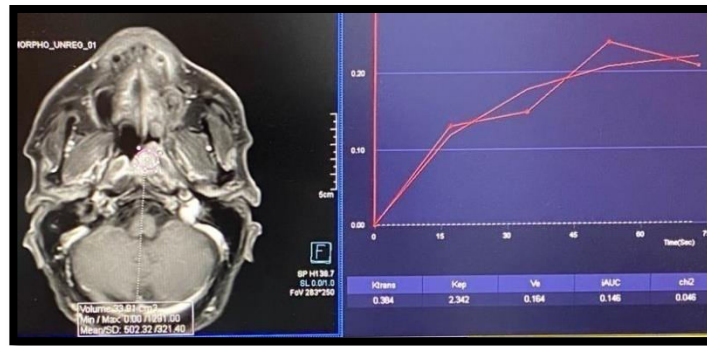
Shows ROI over a primary nasopharyngeal mass before (below image) and after (above image) treatment with the DCE-MRI parameters obtained in both settings.
